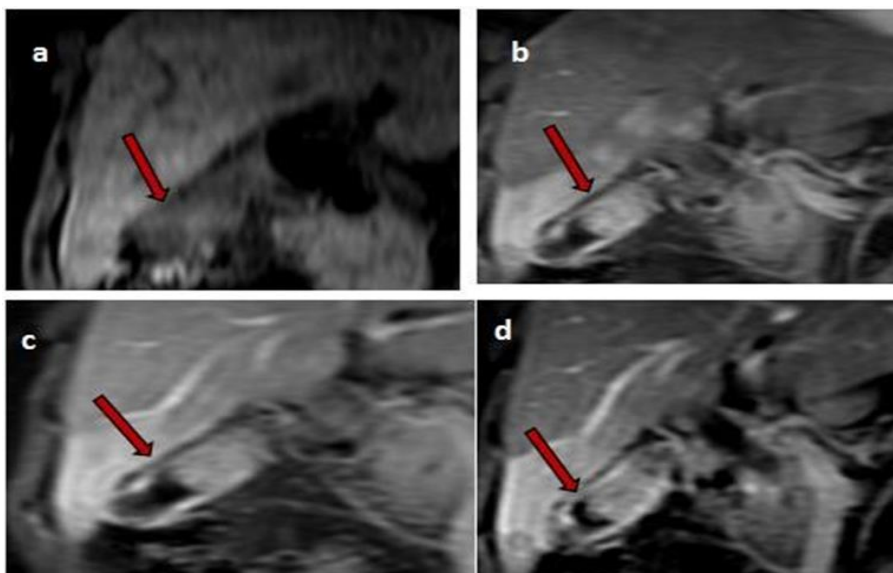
MRI of a 52-year-old female of GBC. Precontrast coronal dynamic contrast image (a) shows hypointense mass in body of the GB (arrow). On post contrast coronal dynamic arterial phase (b) shows avid enhancement of the mass (arrow) shows with persistent enhancement in portal venous phase (c) and hepatic venous phase (arrow) (d).
